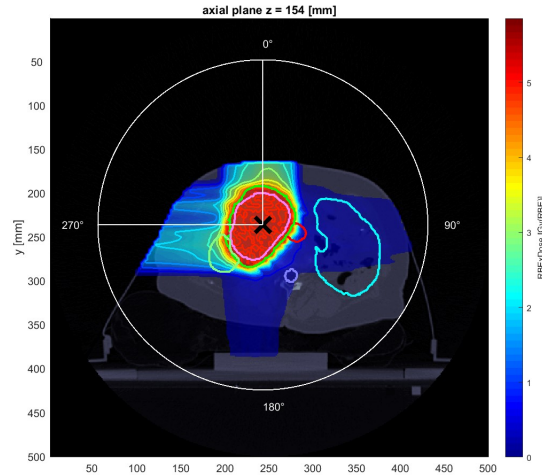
Replicated treatment plan on reference CT
